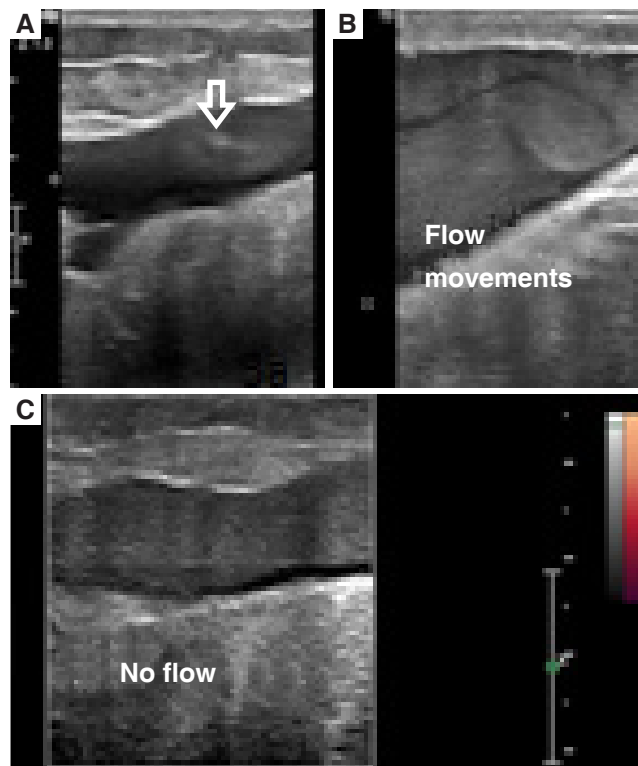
Ultrasound images showing the movement of the fluid. (A) few uniform soft echoes within the fluid (white arrow) because of haemolymph; (B) flow moments in the fluid because of different density of blood and lymph; (C) no color flow seen in and around the cystic fluid in color flow imaging
